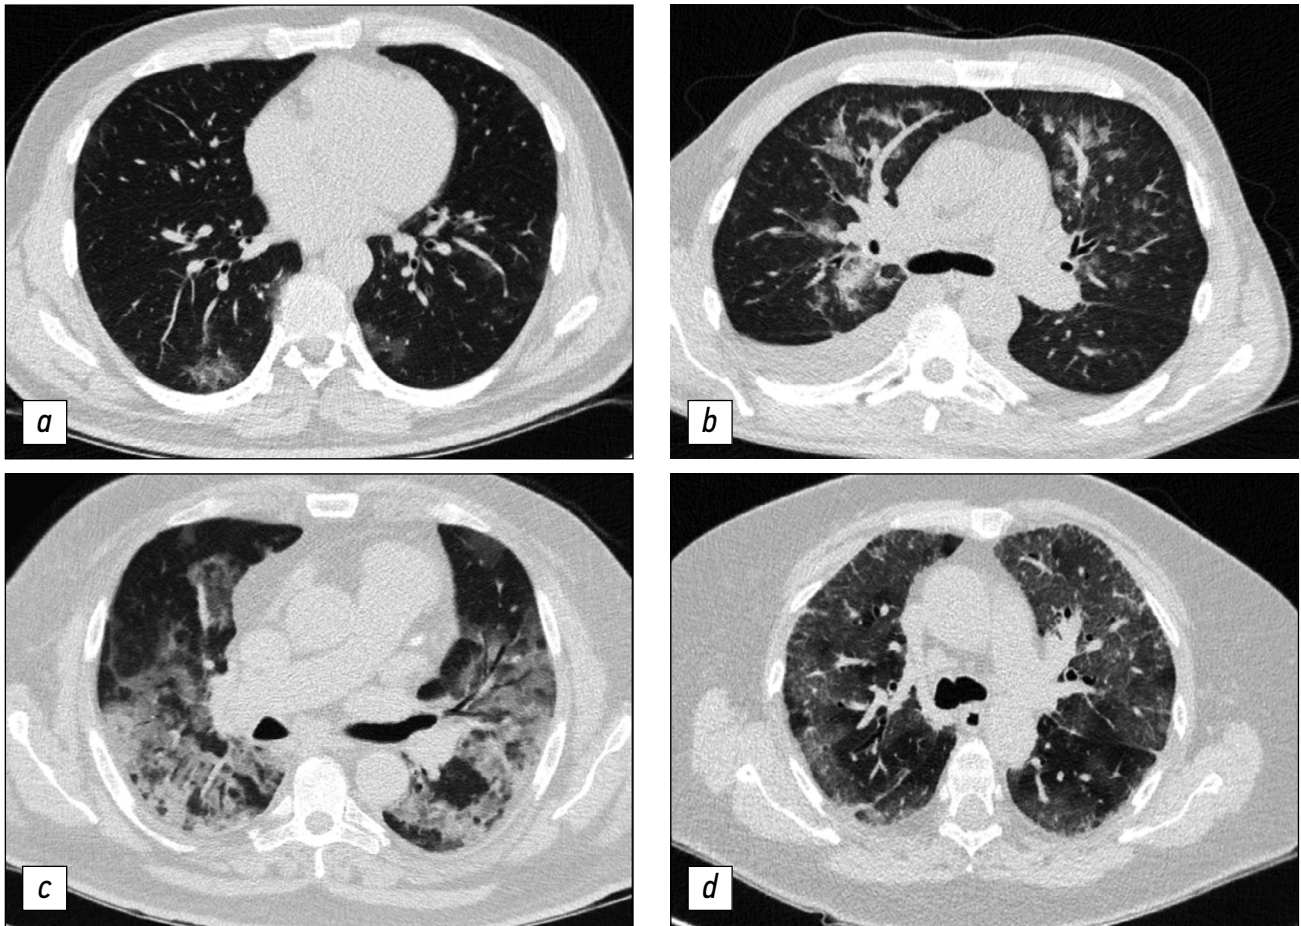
Viral pneumonia severity according to the computed tomography of the thoracic organs: *a* — mild changes (CT-1), involvement of the lung parenchyma by $\leq 25\%$; *b* — moderate changes (CT-2), involvement of the lung parenchyma by $25\%–50\%$; *c* — severe changes (CT-3), involvement of the lung parenchyma by $50\%–75\%$; *d* — extremely severe and critical changes (CT-4), involvement of the lung parenchyma by $\geq 75\%$.
